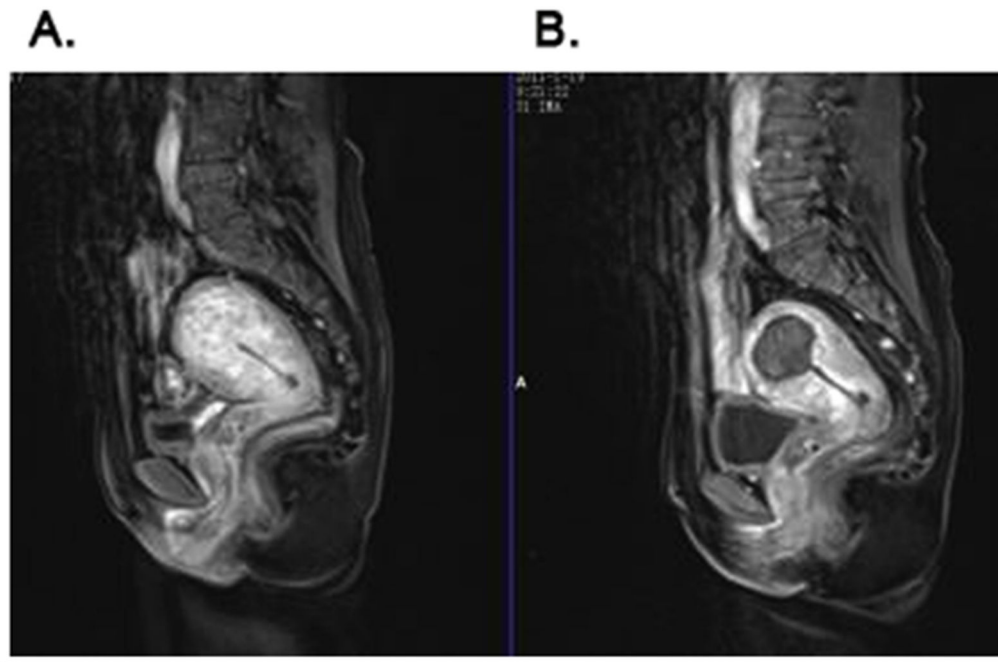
Preoperative and postoperative enhanced MRI. (A) Enhanced MRI of adenomyosis before treatment which shows the thickening of the myometrium in fundus of uterus and rich blood supply. (B) Enhanced MRI from a patient with adenomyosis 1 day after HIFU treatment, which shows non-perfused area in the lesion. Reprinted from *Ultrasonics Sonochemistry*, Vol. 27, Shui L, Mao S, Wu Q, et al. High-intensity focused ultrasound (HIFU) for adenomyosis: Two-year follow-up results, Pages 677-681 (2015) with permission from Elsevier⁶⁵.
